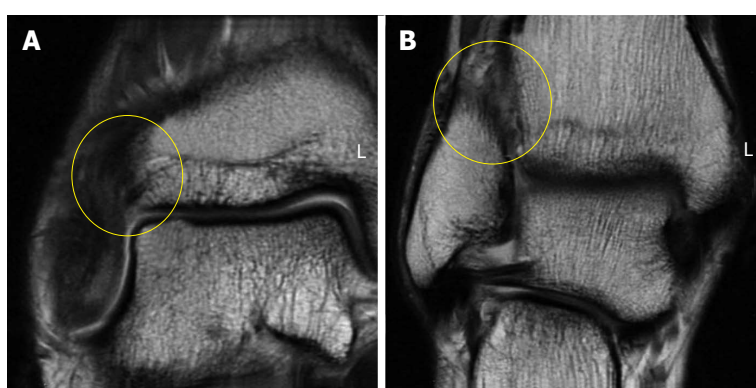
Coronal fast-spin echo proton density magnetic resonance images of the right ankle seen in Figure 1. Disruption and remodeling of the anterior inferior tibiofibular ligament (A; yellow circle) and interosseous ligament (B; yellow circle) can be appreciated.
